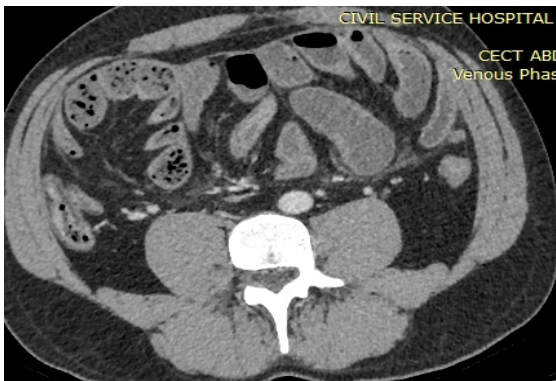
CT contrast axial images showing mild dilated small bowel loops with thin surrounding capsule.
